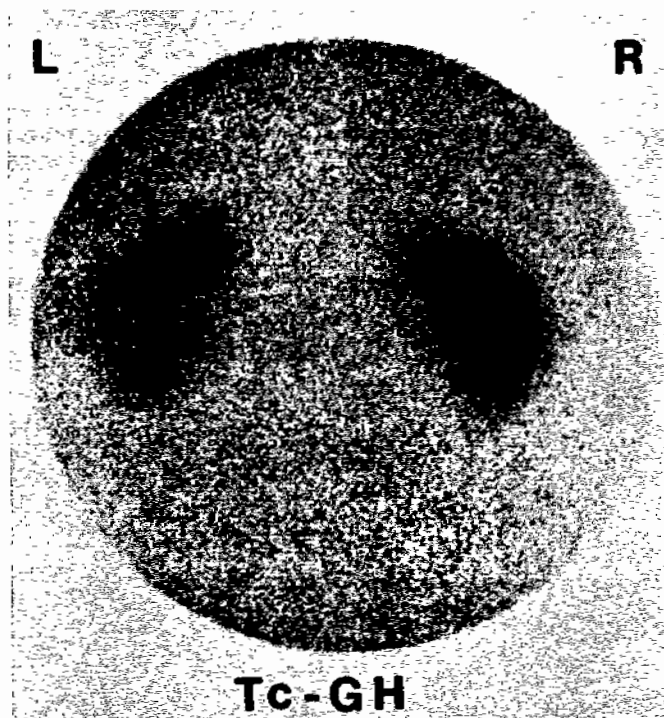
Posterior static renal image made with ^{99m}Tc -glucoheptonate (glucoptate) (*Tc-GH*) shows focal areas of relatively increased activities in the upper portion of both kidneys. Mass lesions without obstructive uropathy were suggested, on intravenous pyelogram, but a renal sonogram was negative.
